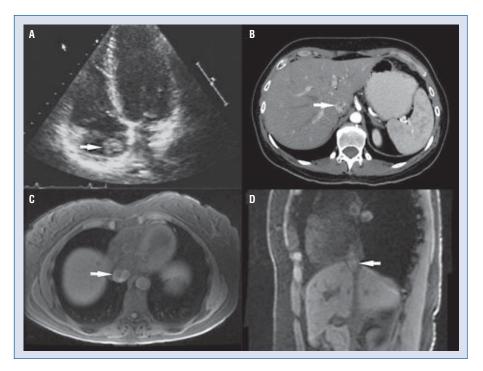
A 49-year-old female with intravenous leiomyoma discovered a right atrial mass arising from the inferior vena cava by echocardiography; A. Transthoracic echocardiography (four-chamber view) showed a round lobular right atrial mass from the inferior vena cava measuring 1.64×1.51 cm in size (arrow); B. Axial computed tomography showed a filling defect in the abdominal inferior vena cava (arrow); C. Axial T₁-weighted spin-echo magnetic resonance imaging showed a filling defect in the abdominal inferior vena cava with tumour thrombus (arrow) with retrograde extension into the right atrium.
